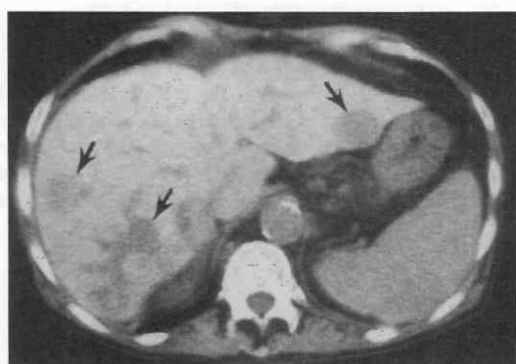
Hemochromatosis with multifocal hepatocellular carcinoma. Unenhanced CT scan demonstrates multiple masses of low attenuation relative to the overall increased density of the liver as a result of the high levels of iron in the liver. The lesion of the posterior segment of the right hepatic lobe has portal vein invasion, which causes the venous dilatation peripheral to the lesion.
